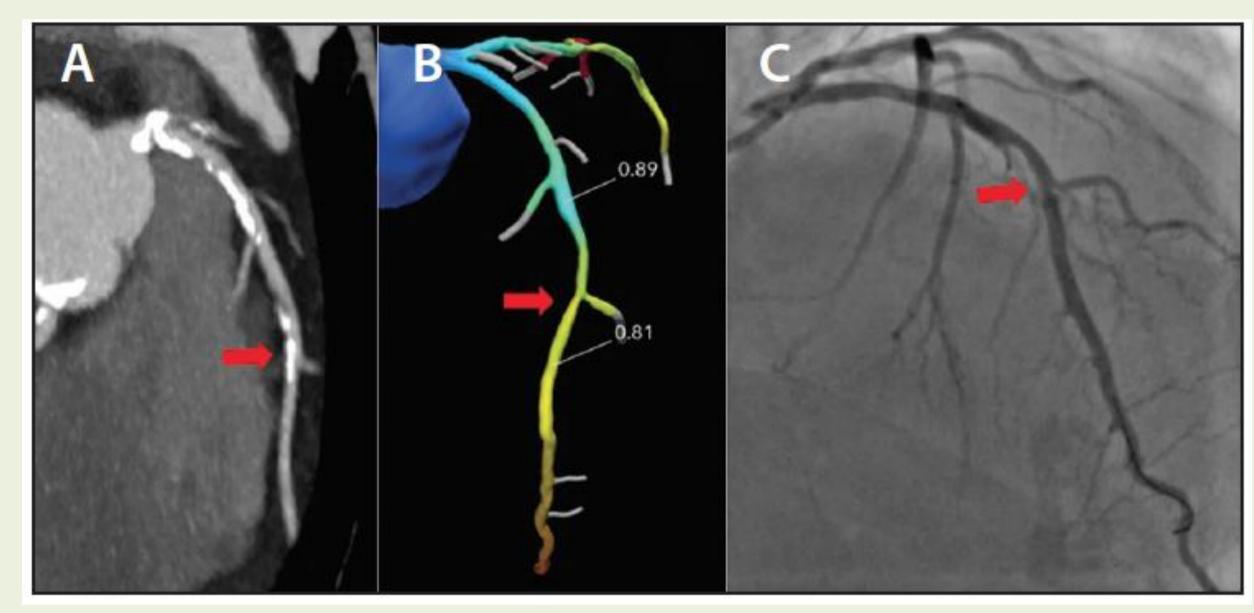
Non invasive FFR-CT of an intermediate lesion in a symptomatic patient with multivessel disease. Panel A shows CCTA (50-70% stenosis), panel B shows FFR-CT (0.81 beyond the lesion), and panel C shows invasive angiography (FFR value of 0.85), supporting the decision-making from FFR-CT⁴.
